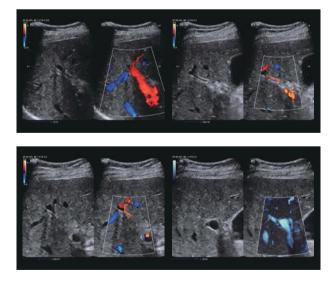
The HA in front of the PV and the HA bifurcation, visualized by the Color Doppler feature and the cUMA and sUMA sub-modes.
